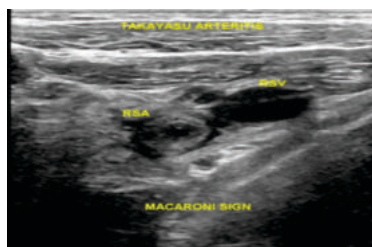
CASE 3: Ultrasound showing concentric echogenic increase in wall thickness of right subclavian artery, the 'macaroni'sign.
